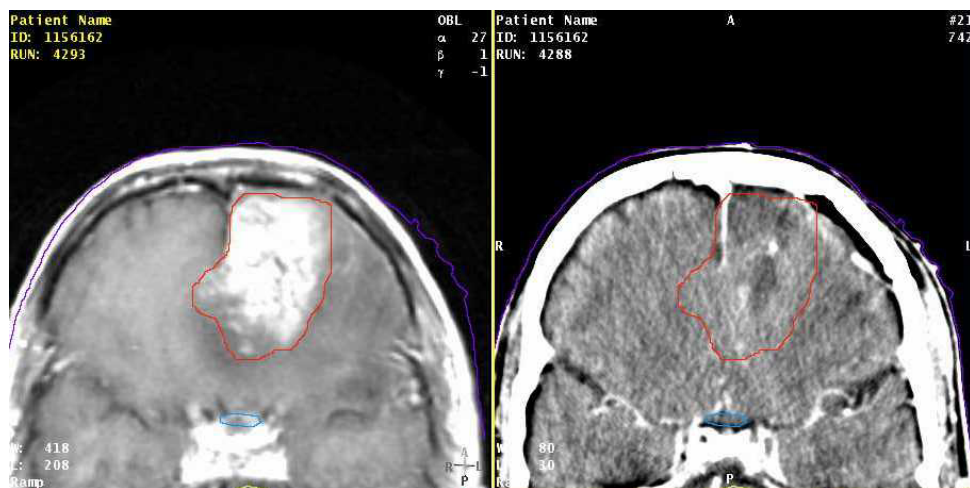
On the left is an MR image of a patient with a brain tumour. The target has been outlined and the result was superimposed on the patient's CT scan. Note that the particular target is clearly seen on the MR image but only portions of it are observed on the CT scan.
